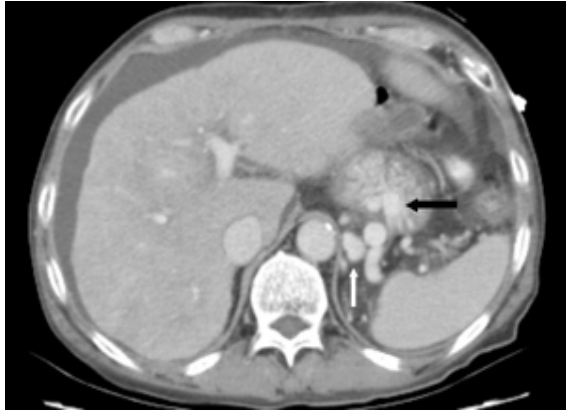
Contrast-enhanced CT scan shows enhancement of the gastric fundal varices (black arrow) and gastrorenal shunt (white arrow). Contrast-enhanced CT scan shows enhancement of the gastric fundal varices (black arrow) and gastrorenal shunt (white arrow).
